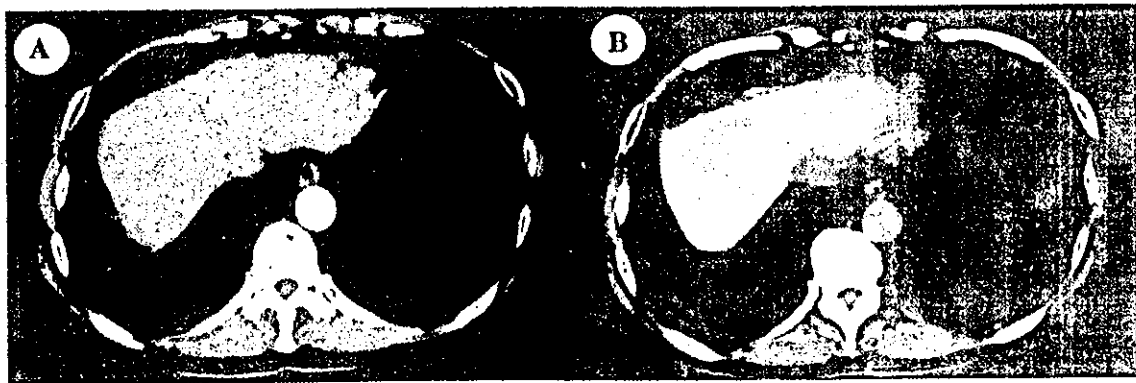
Contrast-enhanced dynamic CT before (A) and plain CT immediately after (B) PELIT for HCC (2 cm) located in the S4 region immediately under the diaphragm. In this case, the tumor was not visible by US. After PELIT, the area of lipiodol-deposit covered the entire tumor and reached beyond the tumor margin.
